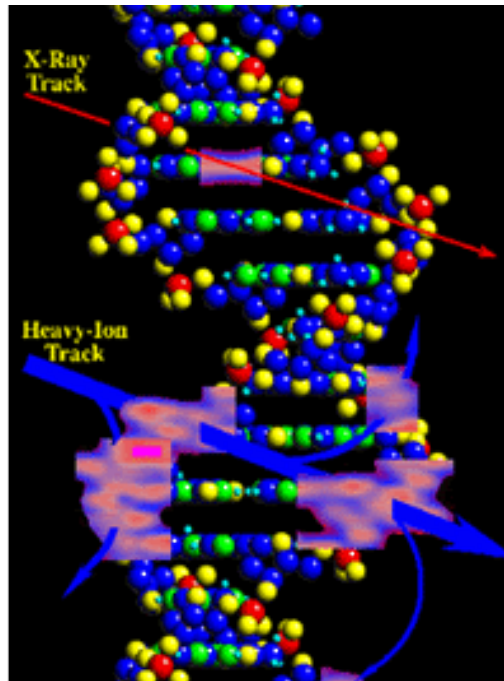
Radiation tracks produced by an X-ray photon and by a heavy charged particle in the DNA double helix
